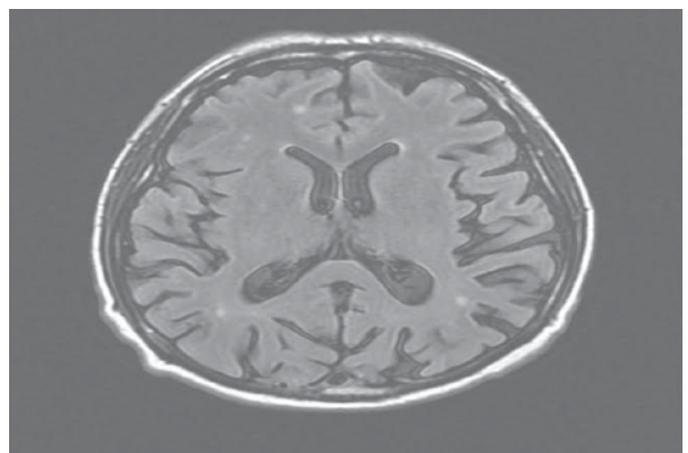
Magnetic resonance imaging scan of brain showing diffuse atrophy.
